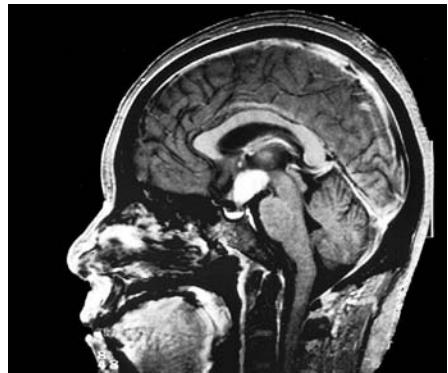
Gadolinium-enhanced MRI of a Langerhans cell histiocytosis in the hypothalamic region (Hand-Schüller-Christian disease).
